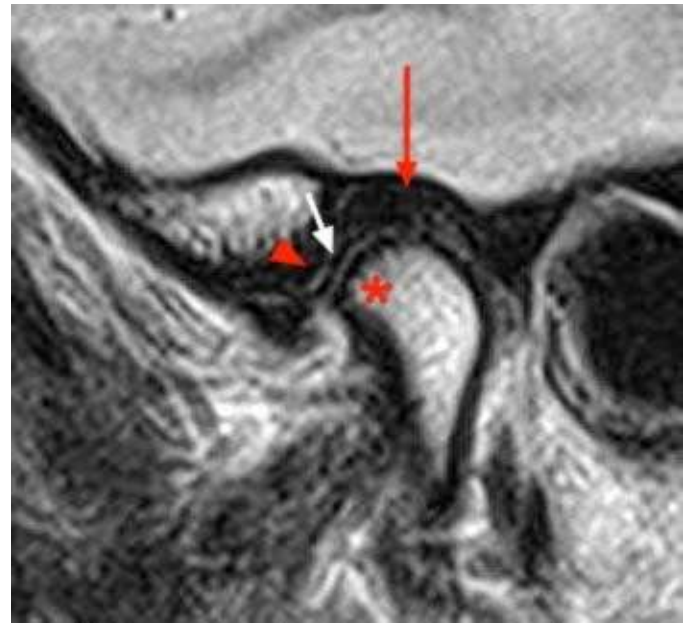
Magnetic resonance image demonstrating normal disc positioning within the temporomandibular joint. The posterior band of the articular disc (red arrow) is located superior to the mandibular condyle, while the intermediate zone (white arrow) is properly interposed between the condyle and the articular eminence. The anterior band is indicated by the red triangle. The red star denotes the normal articulation between the condyle and the articular eminence in the closed-mouth (rest) position.
